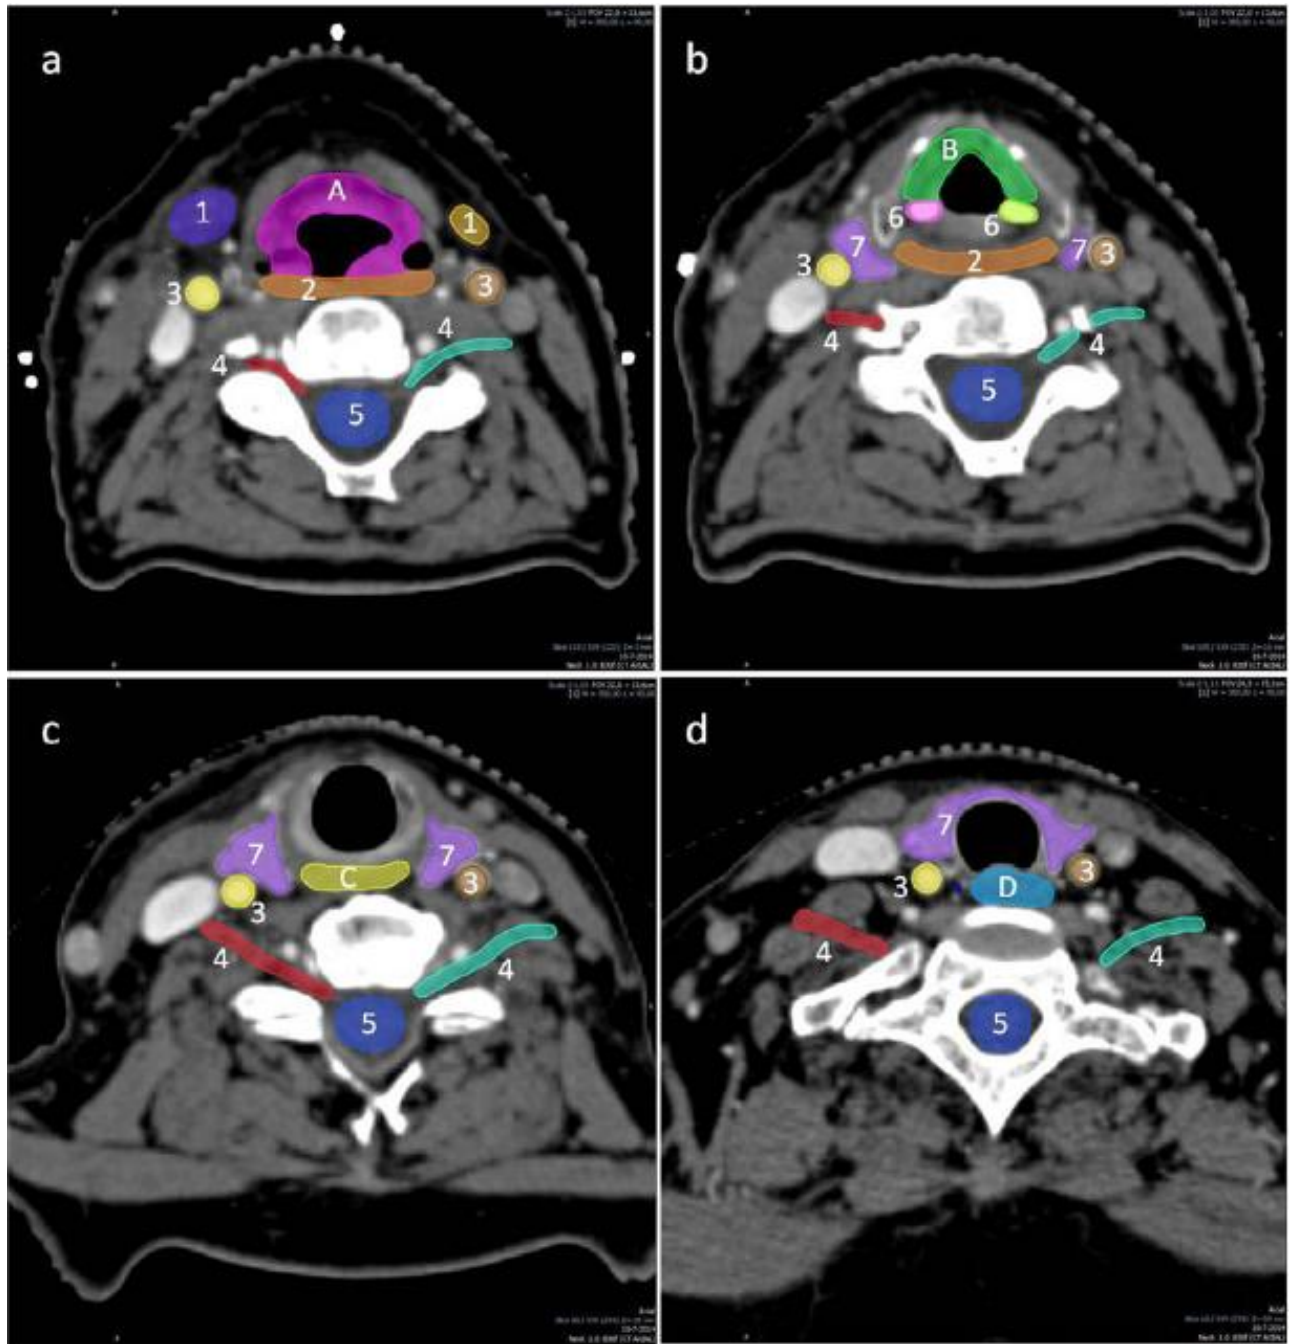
Figure (vi): Axial CT slices of neck region: Showing delineation of the supraglottic larynx (A) glottic area (B) cricopharyngeal inlet muscle (C) and cervical oesophagus (D). Other organs at risks visible are the submandibular glands (1), pharyngeal constrictor muscles (2), carotid arteries (3), brachial plexus (4), spinal cord (5), arytenoids (6) and thyroid (7).
